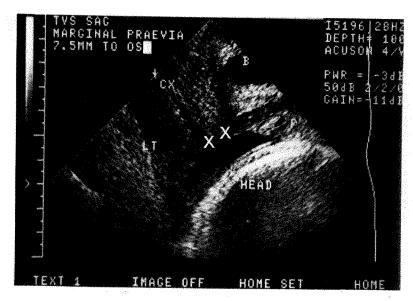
Transvaginal ultrasonographic scan at 34 weeks' gestation. Cervical canal is clearly visible (CX) and distance from internal os to placental edge, measured between calipers (X), is 0.75 cm. The patient was delivered by cesarean section 4 weeks later because of vaginal bleeding. P, Placenta; B. bladder.
